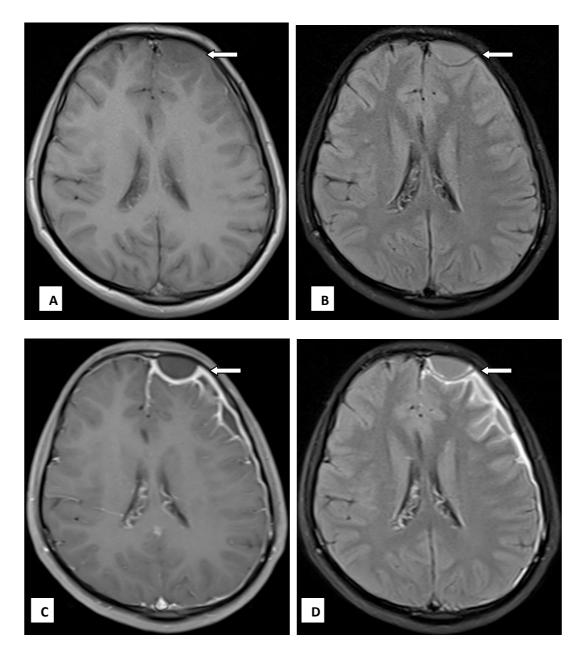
An 18-year-old male patient presented with headache and was diagnosed with epidural abscess & meningitis. MRI axial sections (A) T1WI & (B) T2 FLAIR sequences demonstrated hypo-isointense lesion with faint peripheral hyperintense rim in left frontal region. (C) T1 FS PC & (D) T2 FLAIR PC sequences showed hypoenhancing lesion with peripheral enhancement along with pachymeningeal & leptomeningeal enhancement. The margins of the lesion better depicted on T2 FLAIR PC sequence compared to that of T1 FS PC sequence. Enhancement of meninges is superior on T2 FLAIR PC than T1 FS PC sequences.
